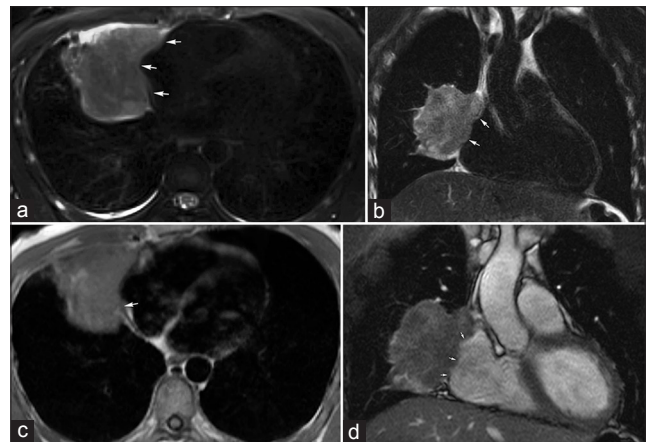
32-year-old male with biopsy-proven sarcomatoid carcinoma involving the right middle lobe. MRI was performed to evaluate disease extent. (a) Axial and (b) coronal T2-weighted images using a PROPELLER/BLADE technique demonstrate the lobulated right middle lobe mass invading the mediastinal fat medially (arrows). (c) Gated double inversion-recovery FSE "black-blood" image shows the loss of the hypotense pericardial line (arrow), and (d) real-time free-breathing bSSFP image shows lack of apparent separation (arrows) highly suspicious for pericardial invasion, a finding confirmed at surgery.
